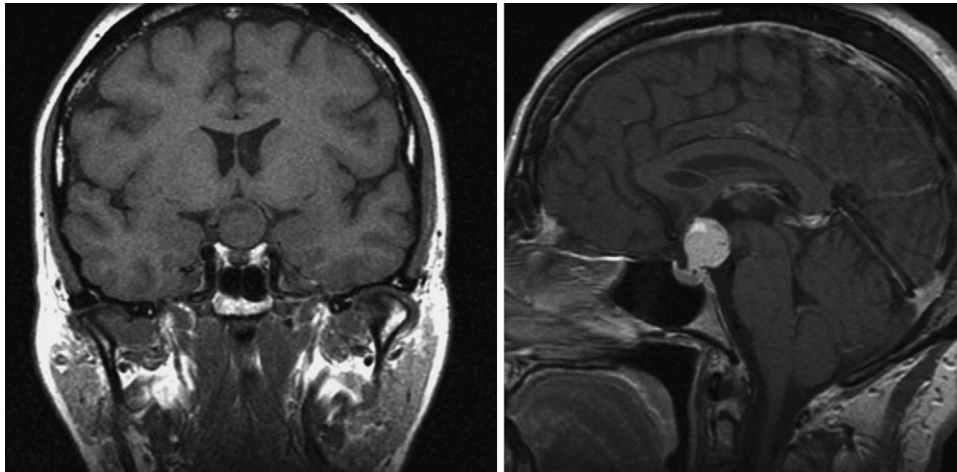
Preoperative T<sub>1</sub>-weighted MR images, coronal without contrast (left) and sagittal with contrast (right), demonstrating an isointense homogenous suprasellar mass which displaced the optic chiasm upwards. The mass strongly enhanced after gadolinium administration and appeared to involve the pituitary stalk.
